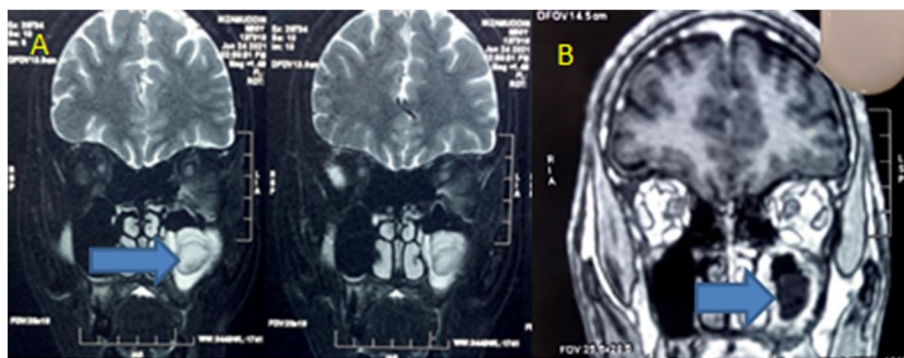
A Fat-suppressed T2-weighted coronal section showing edema in peripheral region and loss of enhancement in the center of left maxillary sinus s/o isolated maxillary mucormycosis
